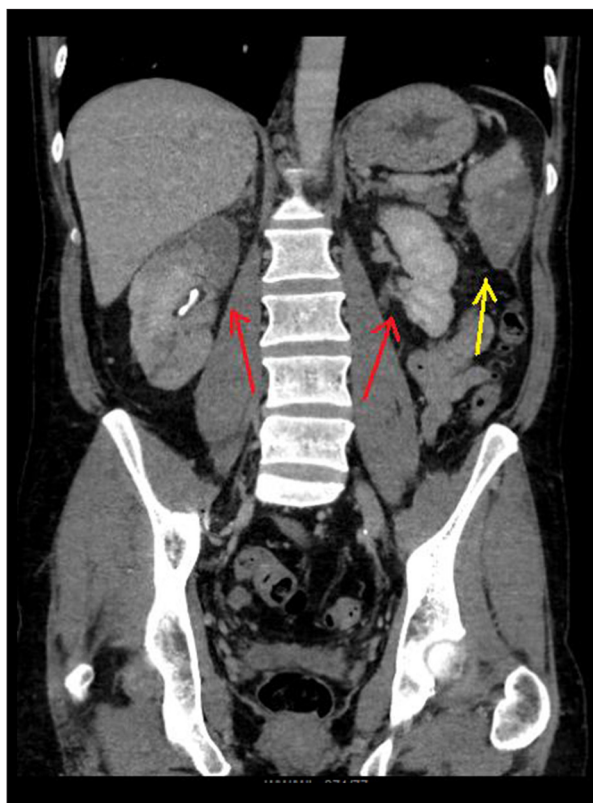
Computed tomography of a right-sided partial renal infarction. In addition, a partial splenic infarction can be seen. The red arrows indicate the kidneys and the yellow arrow the spleen.
